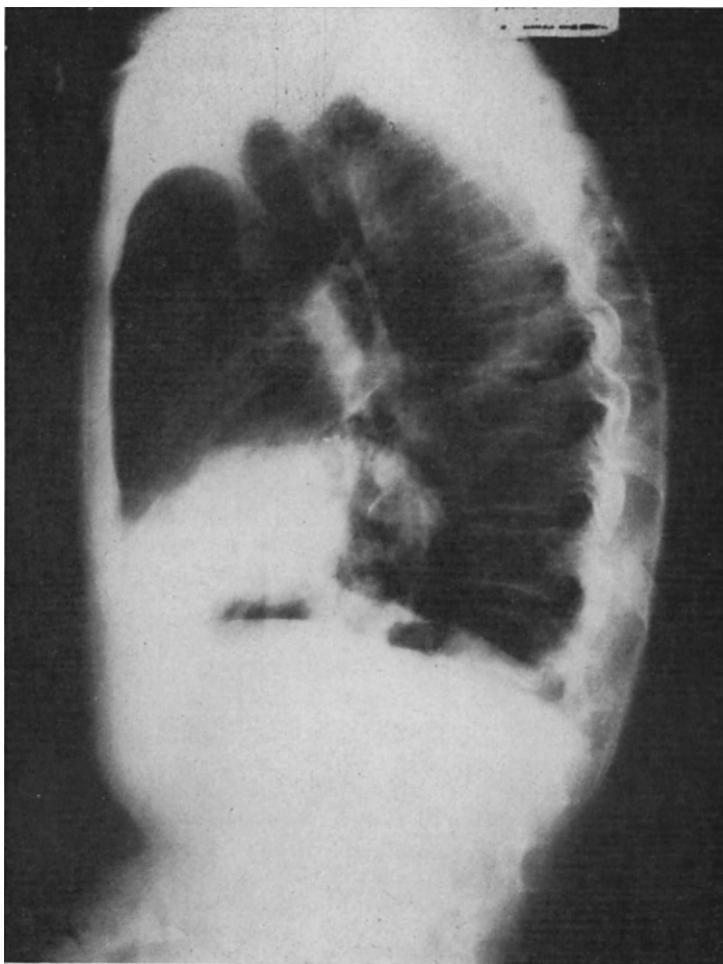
Corresponding left lateral chest radiograph.
